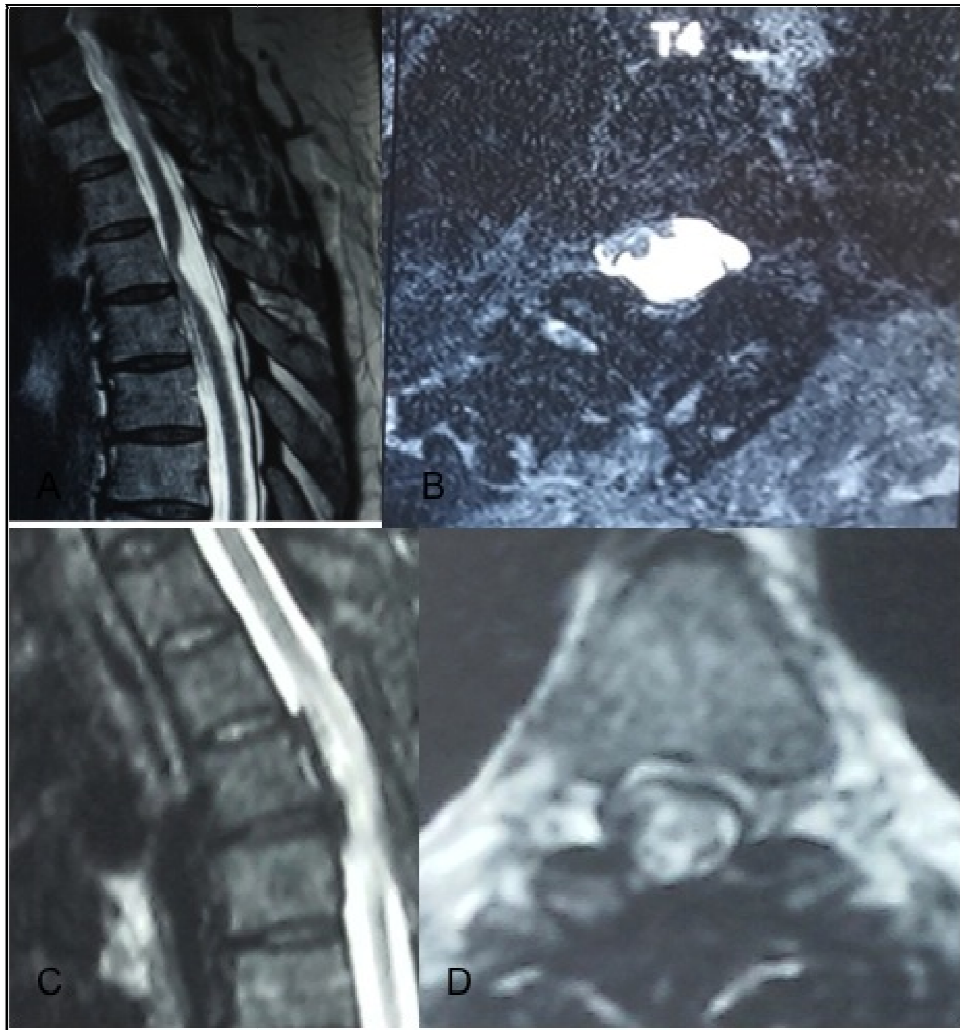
Sagittal MRI (A) showing the characteristic ventral kink with enlarged dorsal subarachnoid space. Axial MRI (B) showing herniation of the spinal cord anterolaterally and complete obliteration of anterior subarachnoid space. Postoperative MRI (C) and (D) at 3 months shows the graft in situ with complete reduction of the previously herniated spinal cord.
